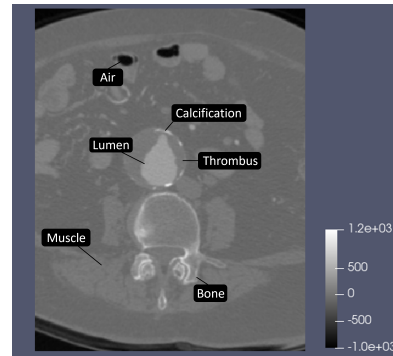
Coronal slice of a CTA scan of the abdomen. The lumen of the aorta is visible, surrounded by thrombus and calcifications.
